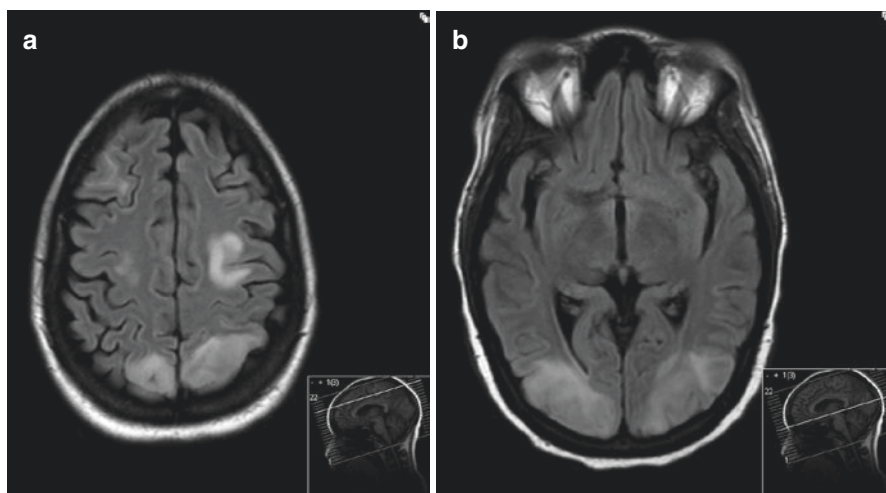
FLAIR sequence MRI showing high signal within the occipital lobes, the precentral gyri and the left frontal white matter. The cortex is swollen. Note that the occipital high signal does not obey the boundary of the territory of the posterior cerebral artery
